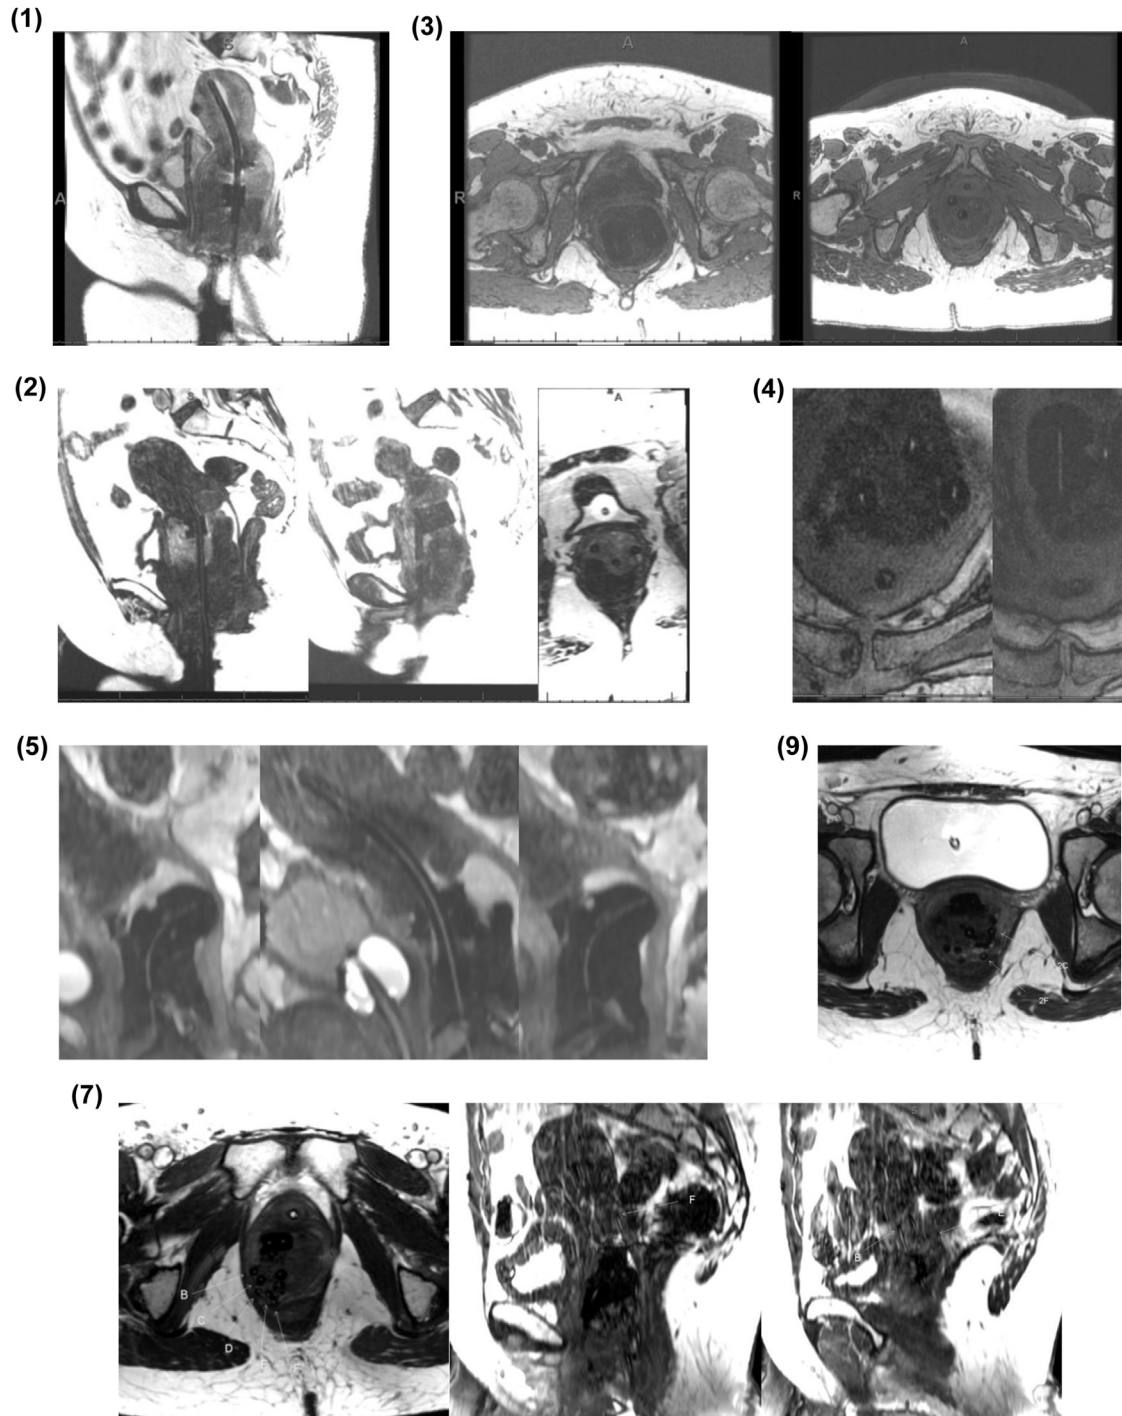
Example 3D-CISS/FIESTA-C MRI images demonstrating visibility of the C4:S line markers within the gynecologic brachytherapy applicators: on 1.5-T (cases 1–3) and 3.0-T (cases 4–5, 7, 9). Labeled by case number. White arrows label catheter positions for interstitial cases (7 and 9).
